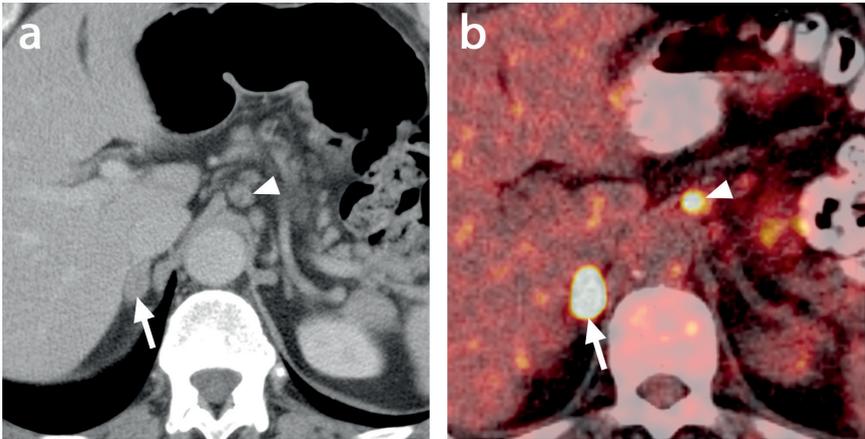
A 72 year-old man was referred to our institution with a biopsy-proven cT3N1M0 adenocarcinoma of the gastro-esophageal junction. In addition to prior endoscopy, EUS, and diagnostic CT (a) at the referring center, we performed a staging ^{18}F -FDG PET/CT (b) that revealed an oval-shaped focus of increased ^{18}F -FDG uptake in the right adrenal gland (arrow). CT-guided biopsy of the lesion demonstrated a metastatic poorly differentiated adenocarcinoma matching the known primary esophageal tumor. In retrospect, with advancing knowledge from the ^{18}F -FDG PET/CT examination the lesion in the adrenal gland may already have been detected on the diagnostic CT from the referring center. Although this patient was referred for treatment with curative intent, the proven M1 disease precluded surgical resection and ^{18}F -FDG PET/CT changed the treatment plan to palliative chemotherapy. *Note* - In addition, an enlarged lymph node just above the celiac trunk was detected on CT (a; arrowhead) and showed intense ^{18}F -FDG uptake on ^{18}F -FDG PET/CT (b; arrowhead). In the most recent (seventh) edition of the TNM-classification, however, celiac node involvement is no longer considered distant metastatic (M1) disease and is no contra-indication for treatment with curative intent.
